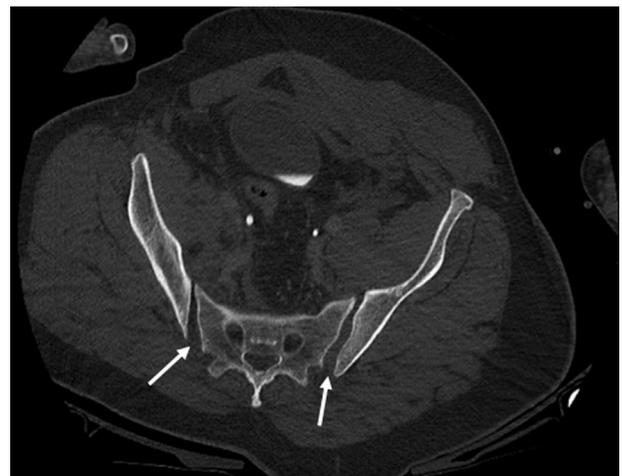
Axial CT of the pelvis in Grade III lateral compression injury: posterior widening of both sacroiliac joints.
